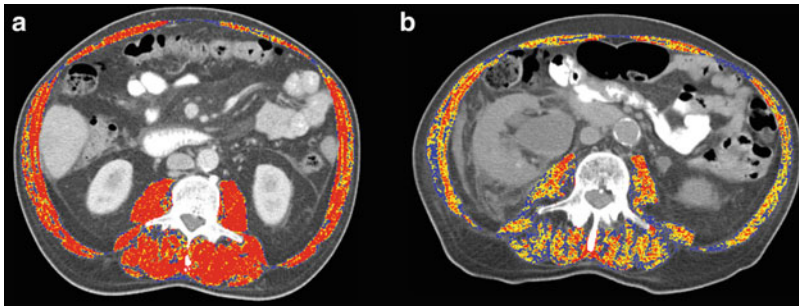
Representative abdominal computerized tomography (CT) images highlighting skeletal muscle differences. Depicts two older adults at the L3 cross-sectional area with the same BMI (BMI = 24), but different quantity (skeletal muscle index A = 47.3 vs. B = 35.3 cm²/m²) and composition of skeletal muscle (mean skeletal muscle density
